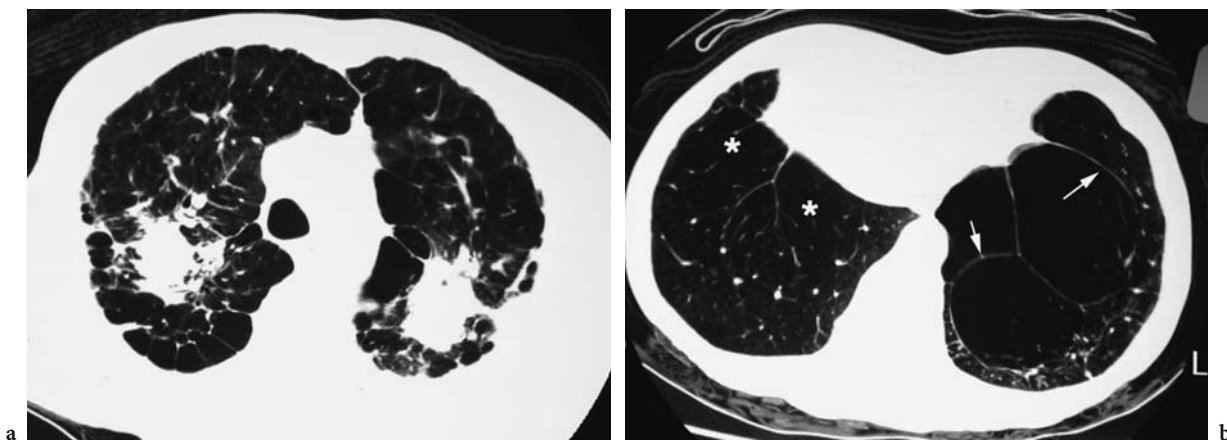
A 74-year-old retired tunnel blaster with progressive massive fibrosis (PMF) complicated by tuberculosis. a Thin-section CT scan through the lung apices shows a cavitating PMF lesion (*arrowheads*) in the right upper lobe secondary to *mycobacterium tuberculosis* infection. Note paracatricial emphysema (*arrows*) surrounding the left PMF lesion and traction bronchiectasis in both lung apices. b Thin-section CT scan through the lower lobes shows a loculated pneumothorax (*arrows*) at the lateral aspect of the left lower lobe secondary to ruptured paracatricial emphysema
